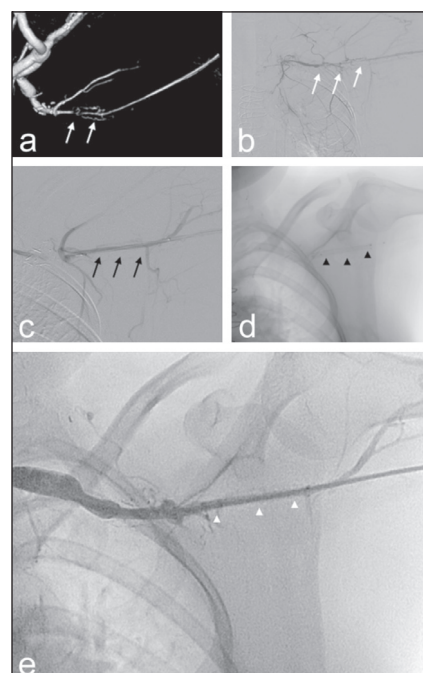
a) b) CT angiography (VRT reformatted image) and DSA angiography, subocclusive lesion of left axillary artery and numerous collateral arteries (white arrows) c) Significantly better width and normal patency of the artery after balloon predilatation (black arrows) d) Stent graft endoprosthesis with heparin bioactive surface implanted in axillary artery (black arrowheads) e) Normal width and patency of the axillary artery after stent graft implantation, with significantly lesser collateral arteries (white arrowheads).
